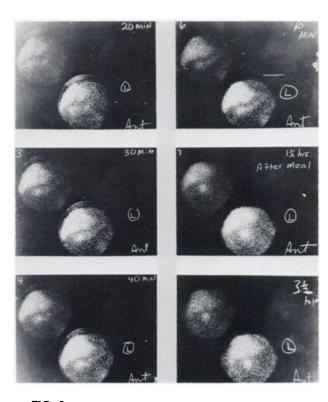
Pancreas scintigraphs at various time intervals. "Hot" area in pancreatic head starts to appear at 30 min and can be clearly seen in 1½- and 3½-hr scintigraphs. Activity in region of pancreas body and tail can be seen up to 60 min.
